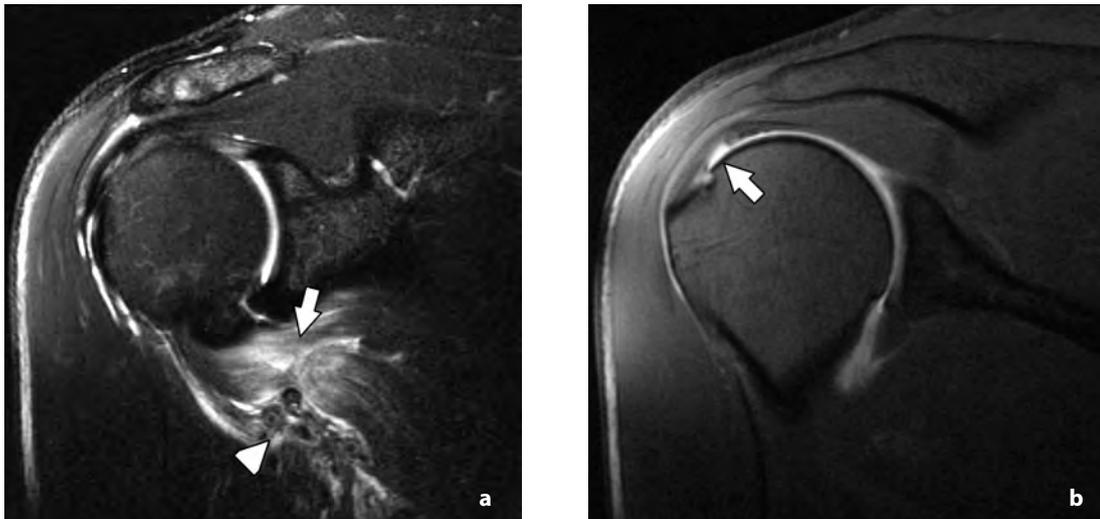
25-year-old, right hand dominant professional baseball player with an acute shoulder injury during off-season pitching: (a) Coronal T2-weighted TSE FS image of the anterior right shoulder shows a partial-thickness tear at the subscapularis musculotendinous junction (arrow). Note high signal intensity in the affected region. Additionally, the axillary neurovascular bundle is seen in close proximity to the site of this tear (arrowhead), (b) Coronal T1-weighted spin echo (SE) FS MR arthrogram image of the same shoulder at the level of the anterior supraspinatus tendon shows contrast undercutting the articular surface of the tendon (arrow), consistent with partial-thickness, articular surface tendon tear.
